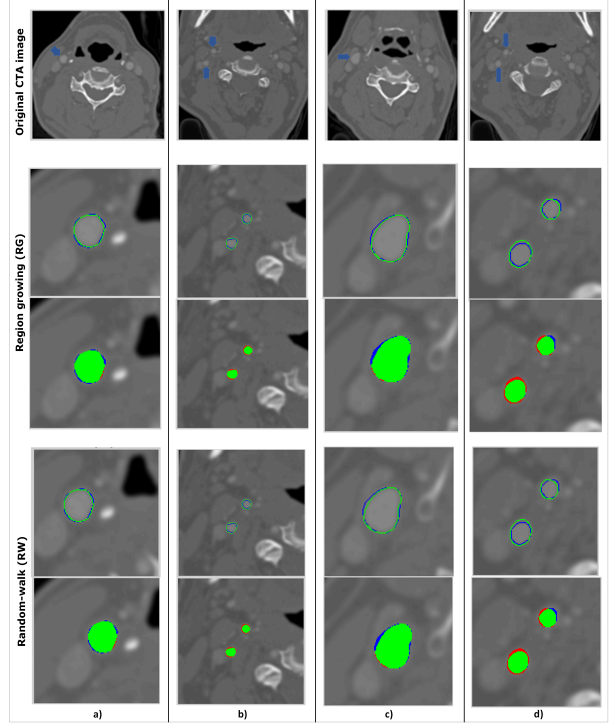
Comparing RG and RW vessel segmentation at same seed points on four different CTA image. (a) for CTA Img.1, (b) for CTA Img.2, (c) for CTA Img.3, (d) for CTA Img.4 and results in Table 1. The second-fourth rows show the vessel edges show green:manuel segmentation, blue:automatic segmentation. The third-fifth rows show the vessels full marked means that green:overlapped(true), blue:over, red:under segmentation.
